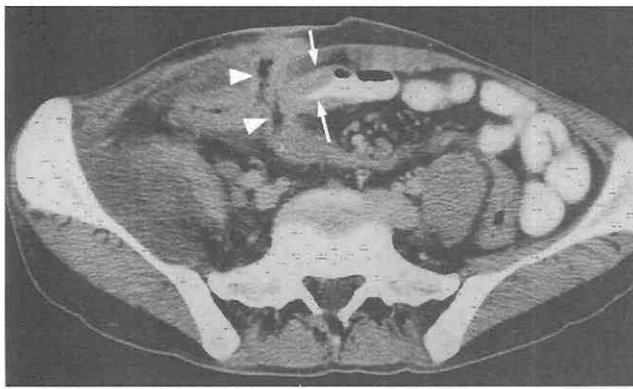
Enterocutaneous fistula in a patient with Crohn's disease. CT scan shows a fistulous tract (arrowheads) and bowel wall thickening of the ileal loop.
